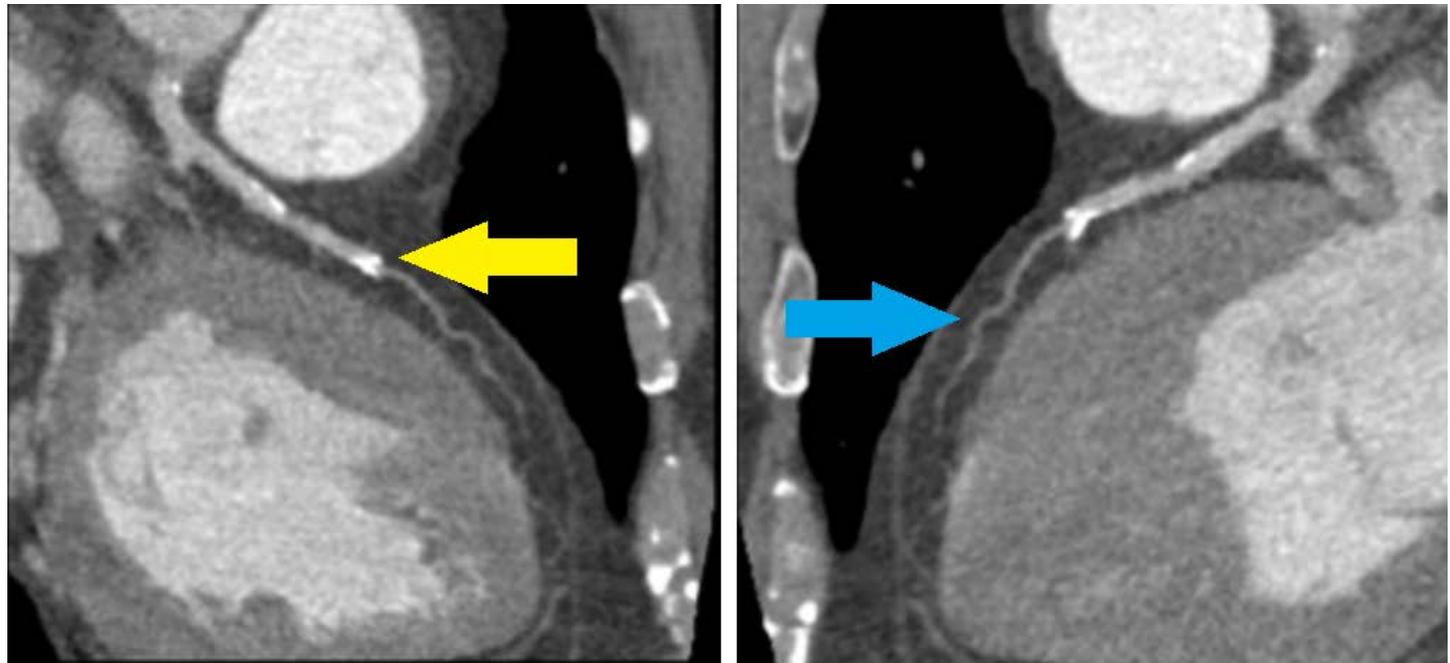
Follow-up CTA of left anterior descending artery (LAD) shows a severe mid-LAD lesion with calcified plaque (yellow arrow) and small distal LAD (blue arrow).
